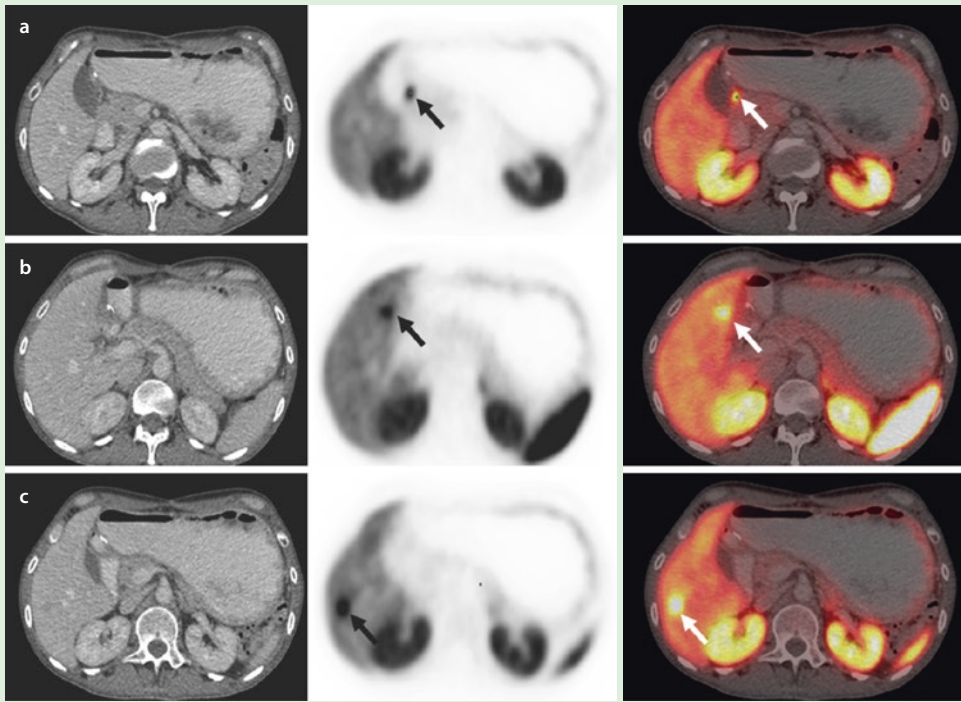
^{68}Ga Gallium DOTATATE PET-CT axial images. a (top row) increased radiotracer uptake (arrow) in the peri-duodenal lymph node; b and c increased radiotracer uptake (arrow) in the metastatic liver lesions
